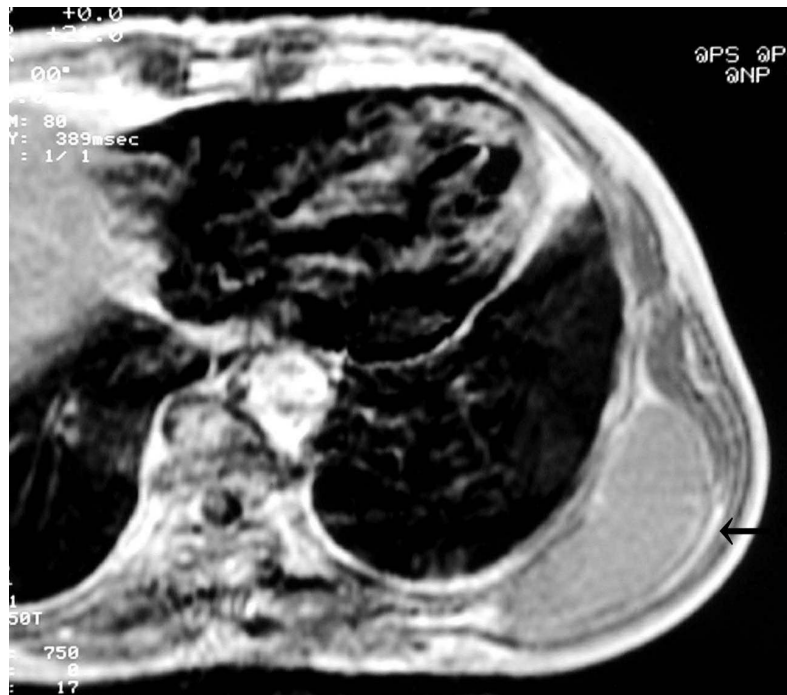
MRI displays well-circumscribed lesion on the thoracic back (the examination was done in the prone position). The mass was located between the serratus anterior muscle and thoracic wall. The tumor had slightly high signal intensity on T1-weighted image (a) and high signal intensity on T2-weighted image with fluid-fluid level (b). The margin of the tumor was enhanced after Gd injection (c).
